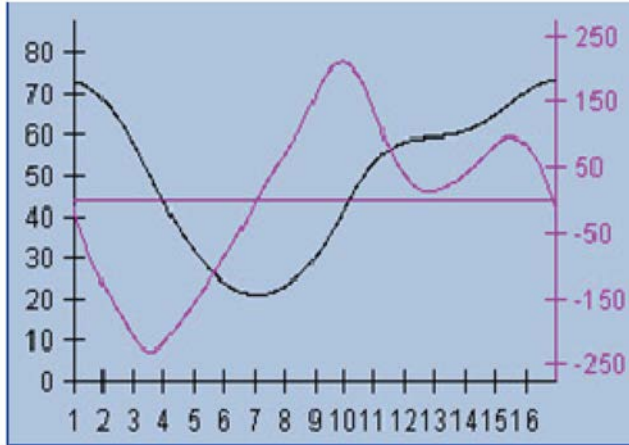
Volume curve of the LV (black curve) of a 16 frame gated SPECT study, showing a normal shape (systolic and diastolic phases). Checking the LV volume curve is a critical aspect of the study QC.
